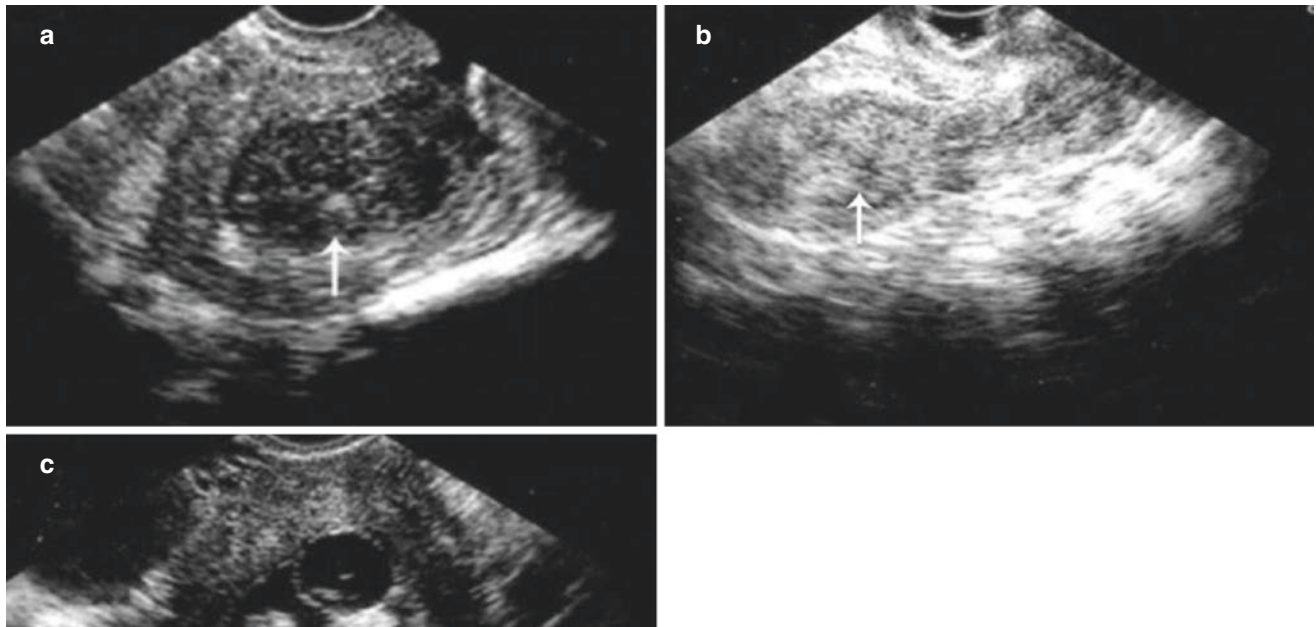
Identification of submucous myoma and endometrial polyp. (a) A patient complained of excessive volume of menses with blood clots for 2+ years. Sonogram shows a hypoechoic mass, 2.4 cm in diameter with a well-defined boundary, in the uterine cavity. (b) A
